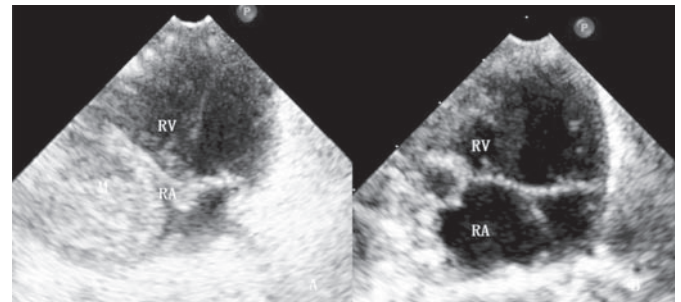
Postnatal echocardiographic image. (A): After Pericardiectomy; (B): After right atrial mass resection. RV, right ventricle; RA, right atrium; M, mass.
